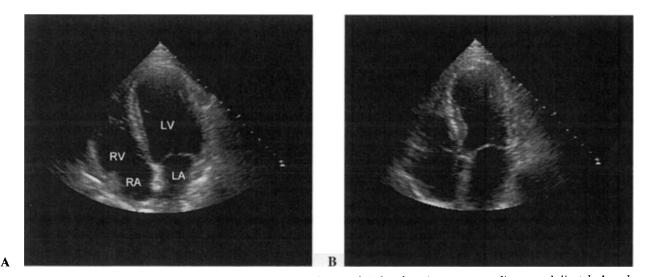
Two-dimensional echocardiographic images in the apical 4-chamber view, corresponding to end-diastole \mathbf{A} and end-systole \mathbf{B} . A reduction in systolic thickening can be appreciated in mid-anterior septal, apical septal, and lateral segments.
